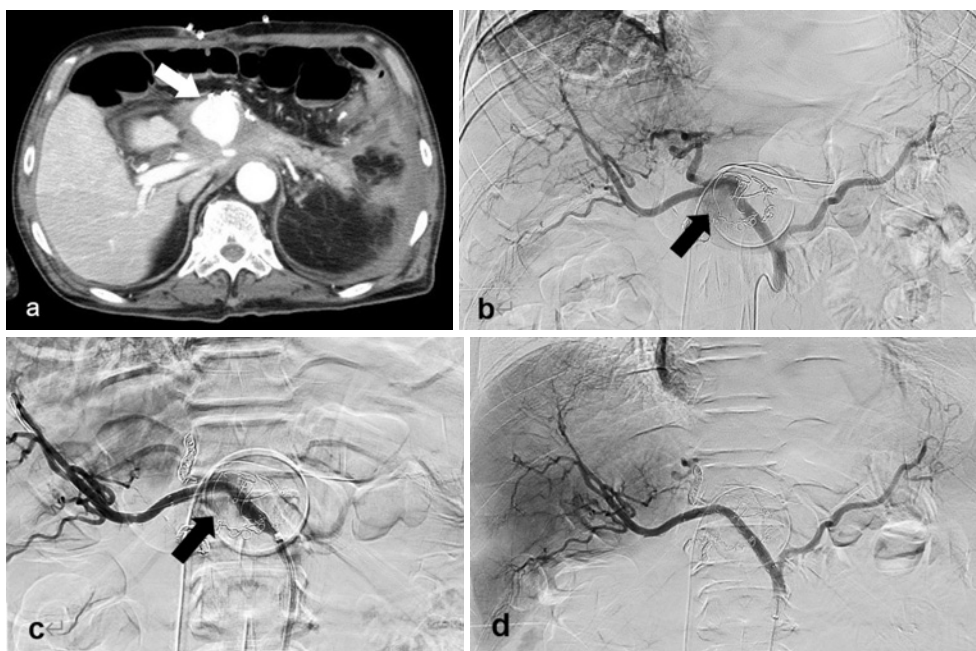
A 72-year-old man who underwent laparoscopy-assisted distal gastrectomy presented with anemia on postoperative day 15. (a) A pseudoaneurysm was found near the proper hepatic artery on the CE-CT (white arrow) and (b) celiac arteriography (black arrow). (c) Coil embolization of the left hepatic artery was performed before SG implantation to prevent type 2 endoleak. Common hepatic arteriography after Viabahn SG implantation (6 mm, 5 cm) showed type 1A endoleak (black arrow), with a proximal neck length measuring 10 mm. (d) Celiac arteriography after additional Viabahn SG implantation (7 mm, 5 cm) to the proximal side revealed the disappearance of pseudoaneurysm.
